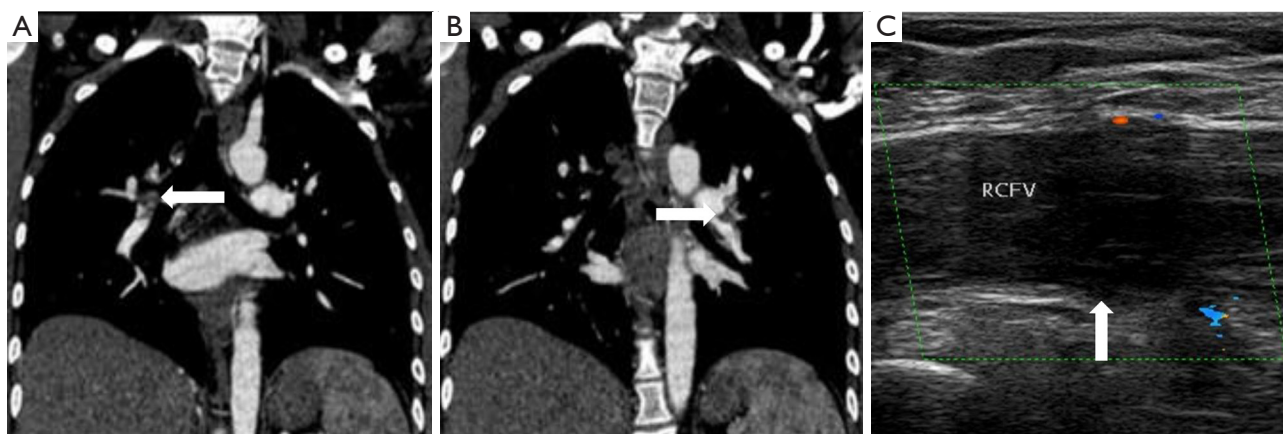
CTA imaging of the patient's pulmonary artery. (A) Thrombosis in the right lung; (B) thrombosis in the left lung; (C) ultrasonography of the right lower limb showed venous thrombosis of the right lower limb. The arrows represent the formation of thrombus. RCFV, right common femoral vein; CTA, computed tomography angiography.
